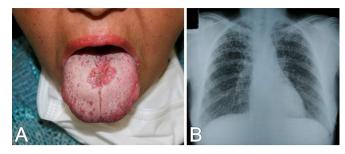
A) clinical aspects of the lesion in the tongue; B) radiographic features of the lungs.
